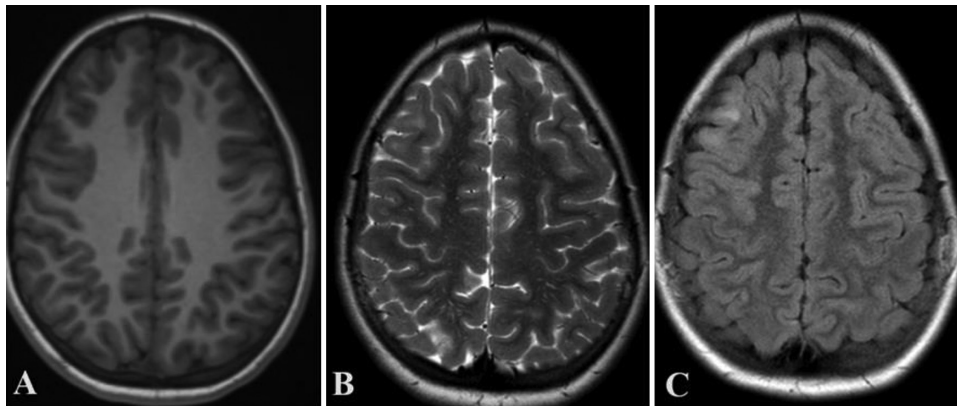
Baseline axial T1-weighted (A), T2-weighted (B), and FLAIR (C) MR images demonstrating an ill-defined T2-FLAIR hyperintense lesion in the right middle frontal gyrus.
